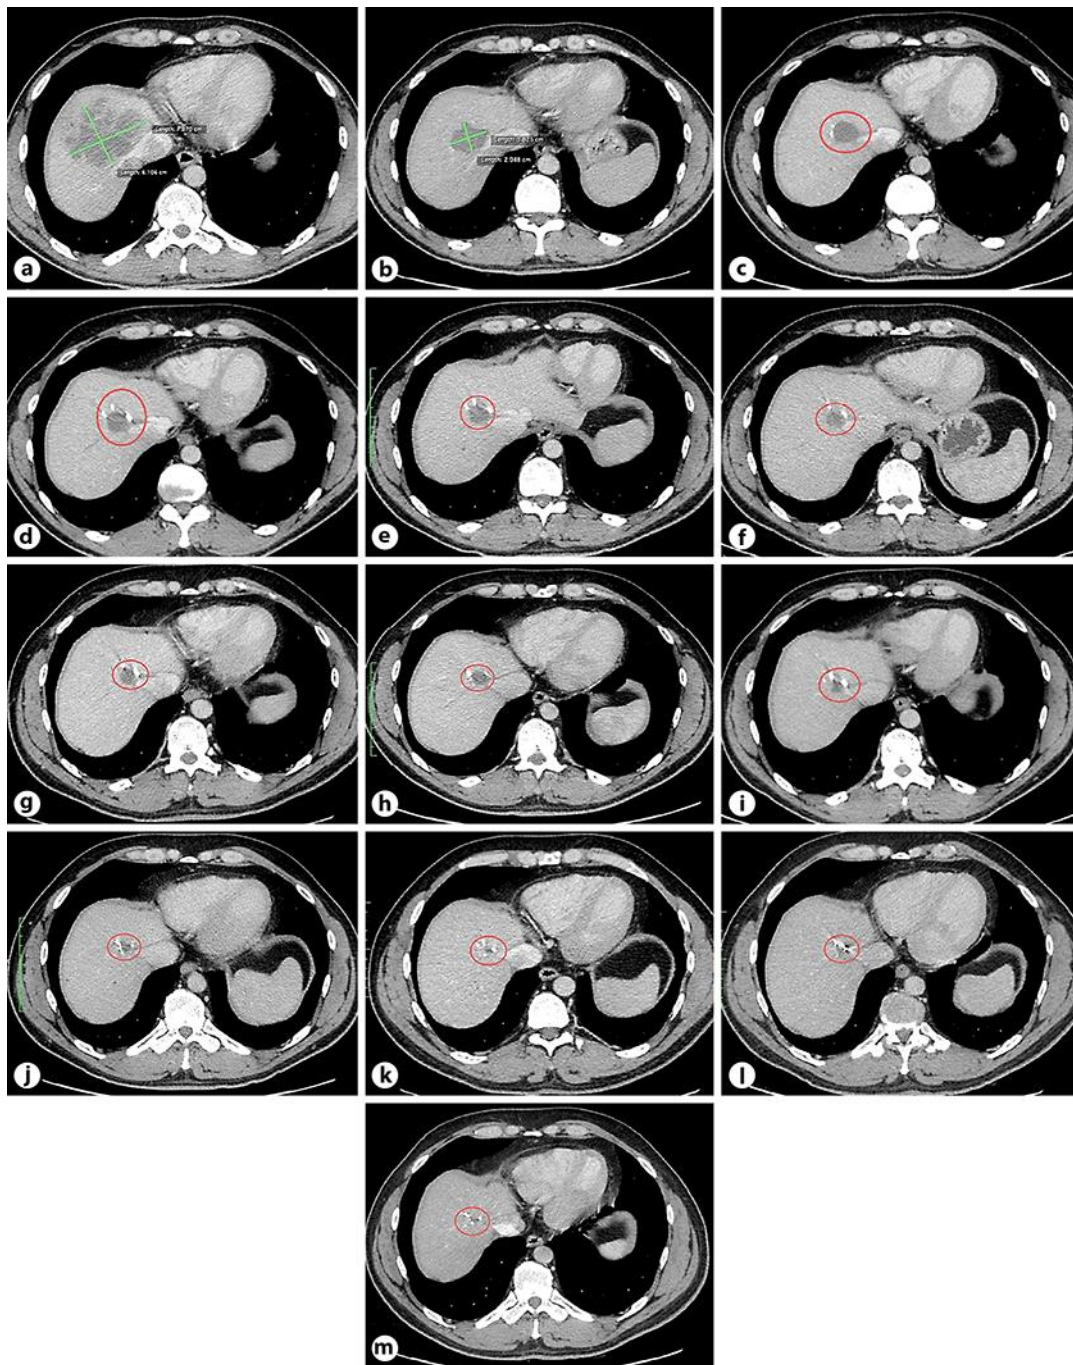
Liver contrast-enhanced CT late-phase scans show that from November 2010 (a) to January 2011 (b) a liver metastasis decreased in size by 50%, 2 months after the start of treatment with FOLFOX-4, bevacizumab, and Rigvir. After partial hepatectomy and postoperative treatment, the residual formation decreased in size and stabilized. c, d August 26, 2011. e November 25, 2011. f February 25, 2012. g August 31, 2012. h March 15, 2013. i September 27, 2013. j August 29, 2014. k September 2, 2015. l August 26, 2016. m November 26, 2016.
